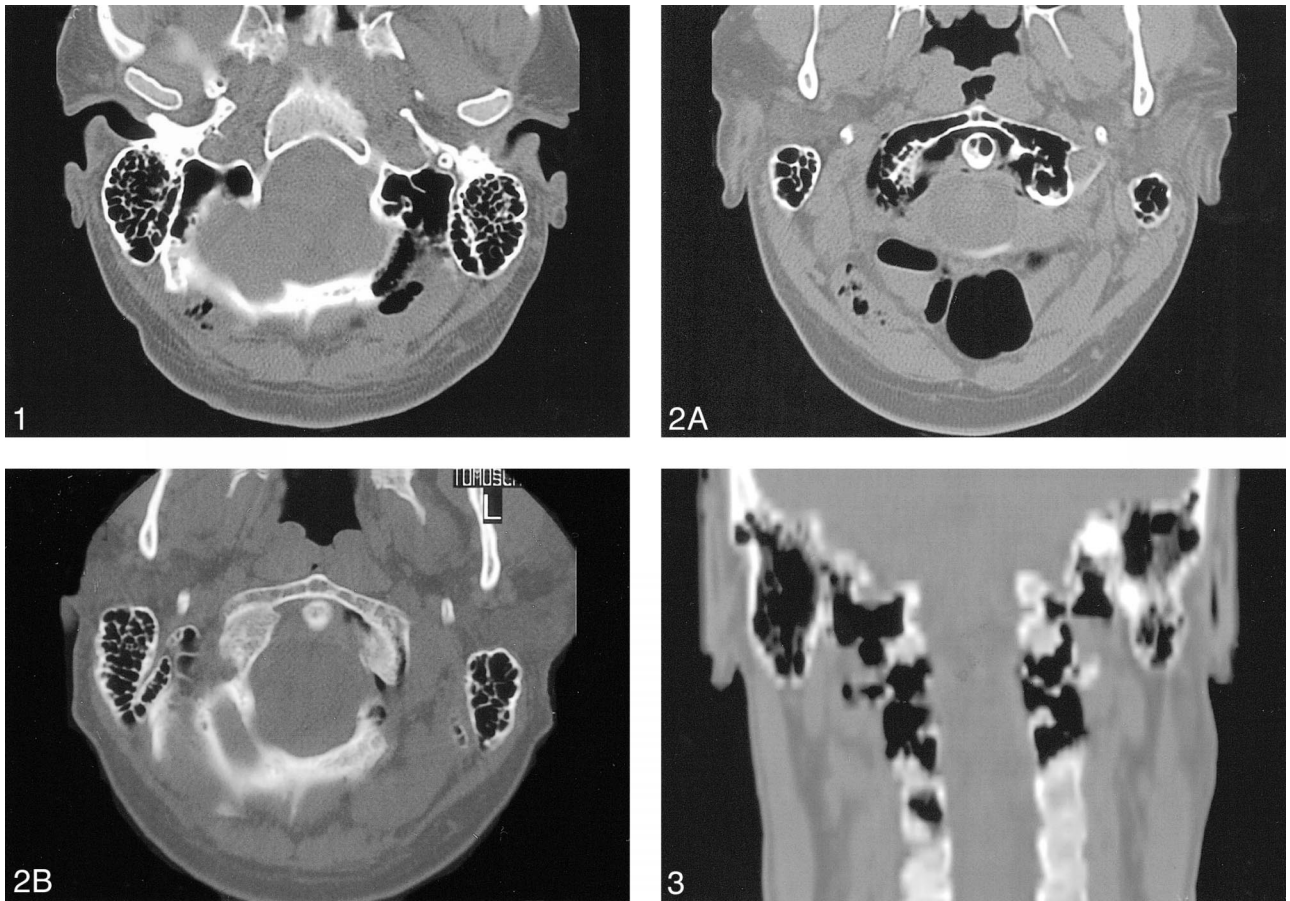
CT of the occipital bone demonstrates extension of mastoid pneumatization to the occipital bone.
